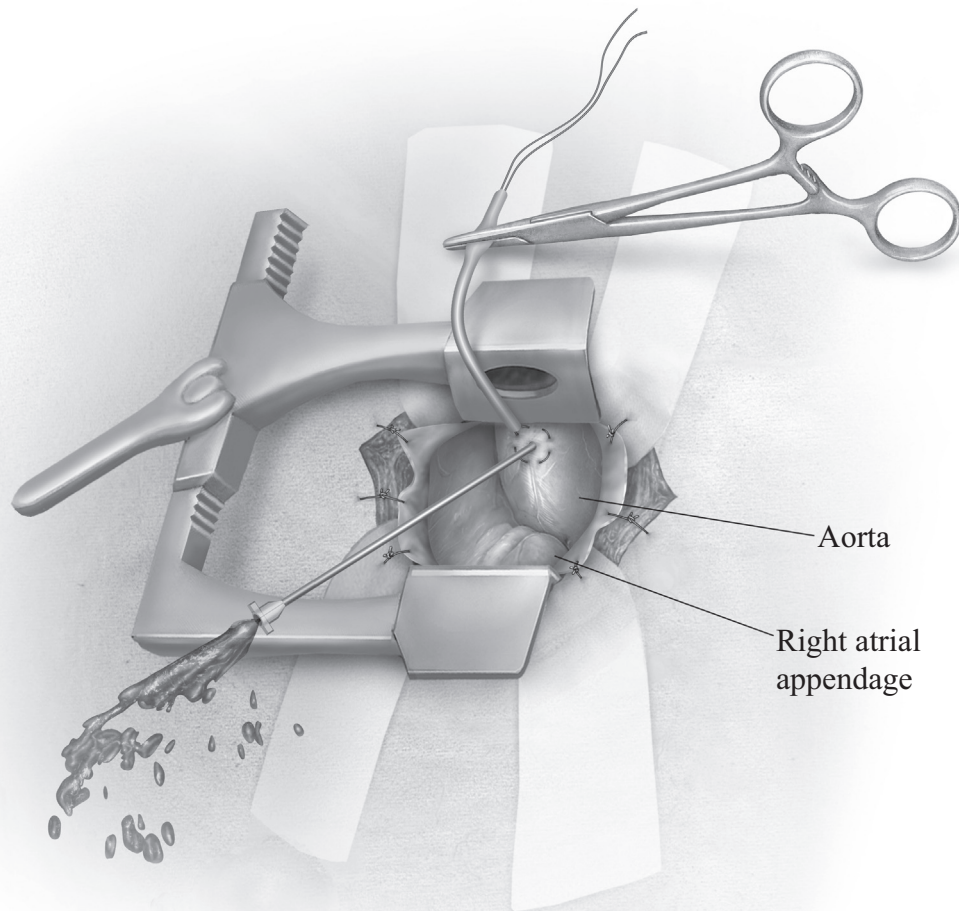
The pericardial edges are hitched to the wound edge to allow exposure of the aorta. The patient is heparinized. The aorta is gently retracted with forceps, and an area for cannulation is identified in the distal aorta. Enough space must be left on the proximal aorta for later placement of a side clamp (Fig. 10). Then, 2 concentric polypropylene purse-string sutures are placed. As access is limited, placement of these sutures is facilitated using long shafted instruments. The ascending aorta is cannulated using the Seldinger technique—this secure and controlled method allows safe cannulation of the aorta from a distance without direct digital control. A wire is advanced through a needle into the descending aorta under transesophageal echocardiography guidance. A suitably sized femoral artery cannula is advanced over this wire. Dilators are not used, but if necessary, the aorta may be incised with a no. 11 blade to facilitate passage of the cannula. The cannula is secured. The right atrial appendage is cannulated with a single-stage cannula (a dual-stage cannula may also be used, but extreme care should be taken to advance this in the direction of the inferior vena cava to avoid perforation of the right atrium, right ventricle, or coronary sinus). If there is difficulty accessing the right atrial appendage, 2 angled venous cannulae are placed in the superior vena cava, or alternatively the femoral vein may be cannulated percutaneously. Cardiopulmonary bypass is instituted, and adequate drainage of the right ventricle is confirmed by echocardiography. The left pleural cavity is flooded with carbon dioxide.
